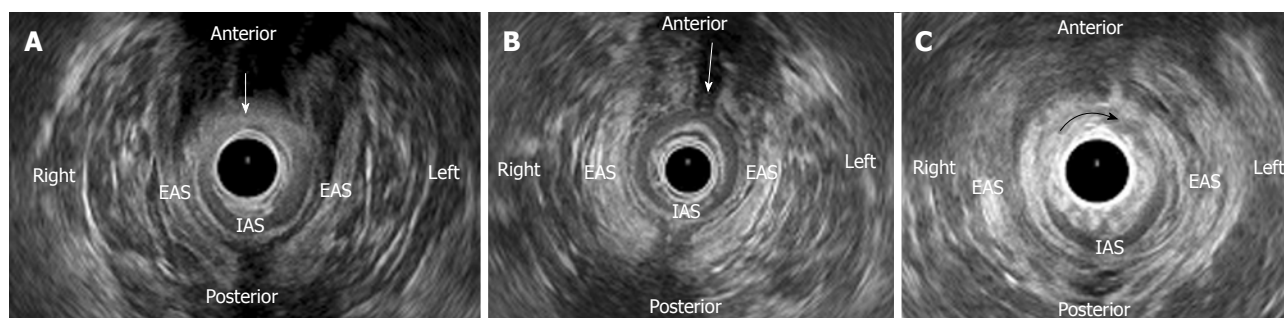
Endoanal ultrasound images of patients with fecal incontinence. A: A combined defect (arrow) of the external anal sphincter (EAS) from 10 to 2 o'clock and of the internal anal sphincter (IAS) from 9 to 3 o'clock positions, in a woman due to an obstetric anal sphincter injury; B: An anterior EAS defect (arrow), in a woman due to an obstetric anal sphincter injury; C: An IAS defect (arrow) from 8 to 4 o'clock position, in a man as a complication of a previous anorectal surgery (due to fistula).
